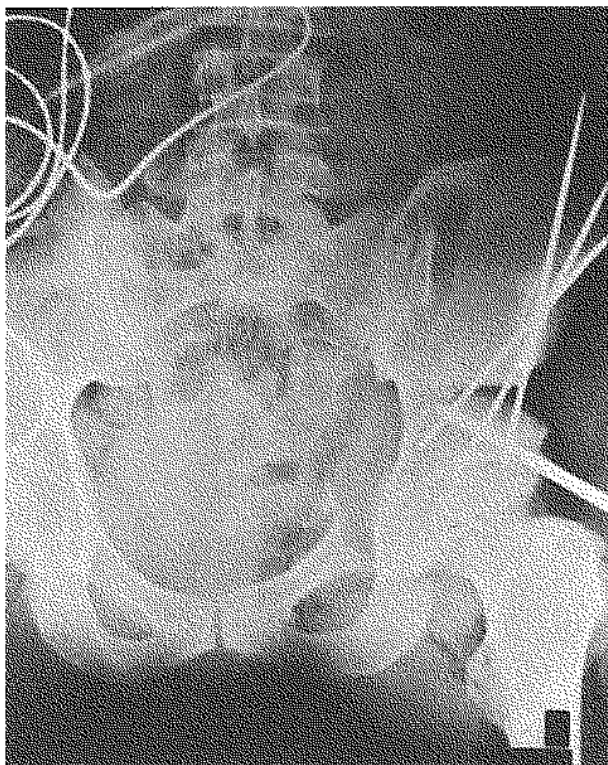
Xray during Ganz osteotomy showing the anterior and posterior rims of the acetabulum.
